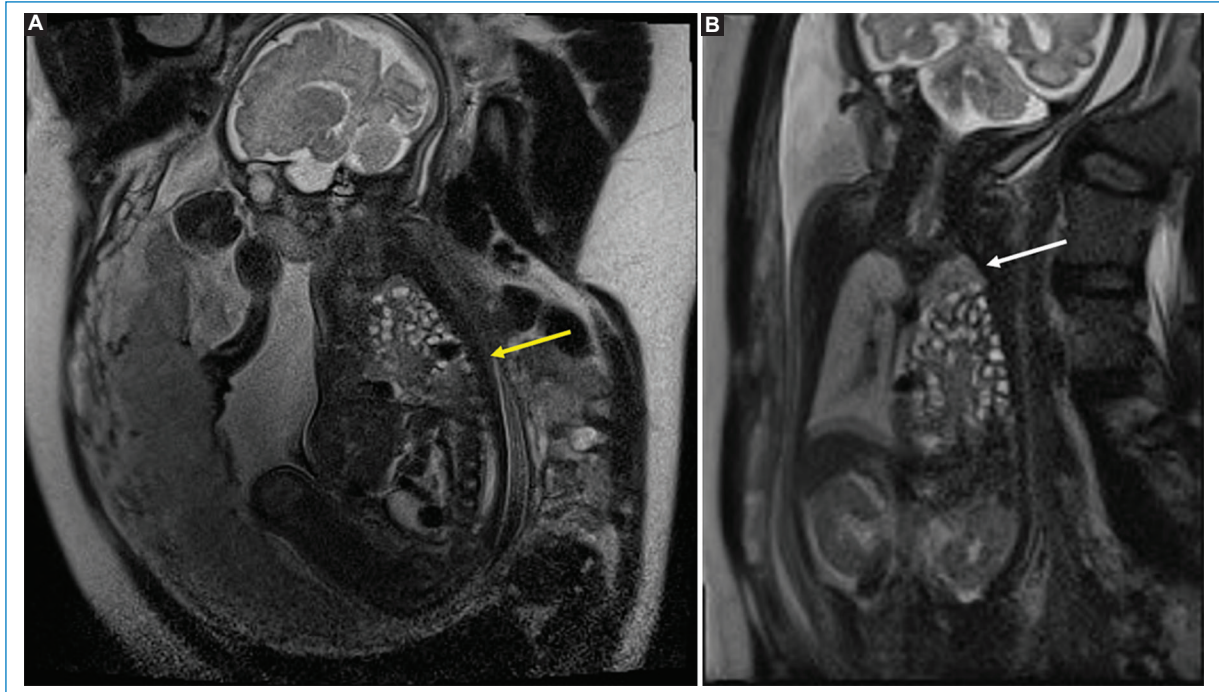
Bochdalek hernia. Selected fetal magnetic resonance images on sagittal (A) and coronal (B) T2-weighted planes. A left dorsal diaphragmatic defect is observed (yellow arrow) with ascent of multiple intestinal loops to the thoracic cavity and ipsilateral pulmonary hypoplasia (white arrow).
